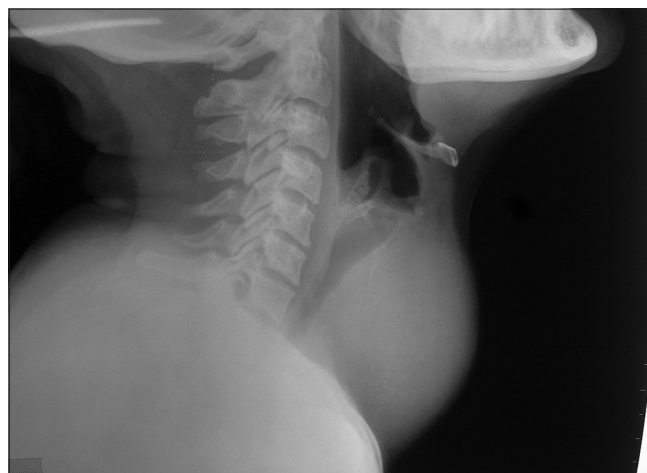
Lateral view of neck X-ray showing the compression of trachea from a longstanding enlarged goiter (thyroid gland)
